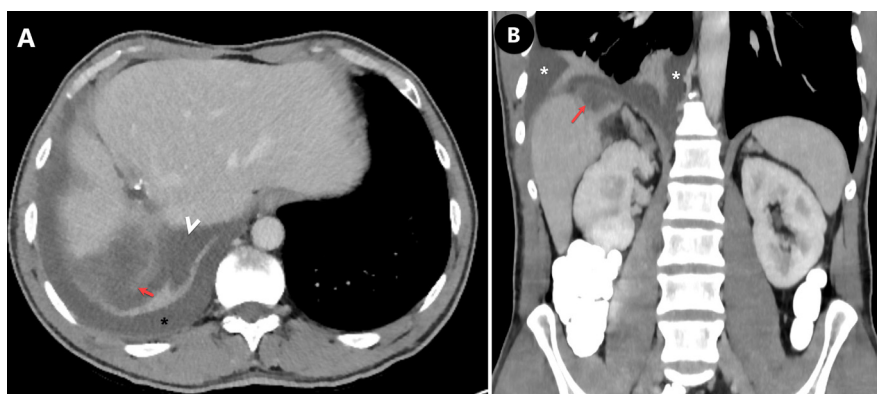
Recently obtained, A) axial and B) coronal contrast-enhanced abdominal computed tomography (CT) images show a thin-walled cystic lesion with lobulated contours in the liver dome (red arrows), pericystic fat stranding, perihepatic free fluid (arrowhead), and right pleural effusion (*).
